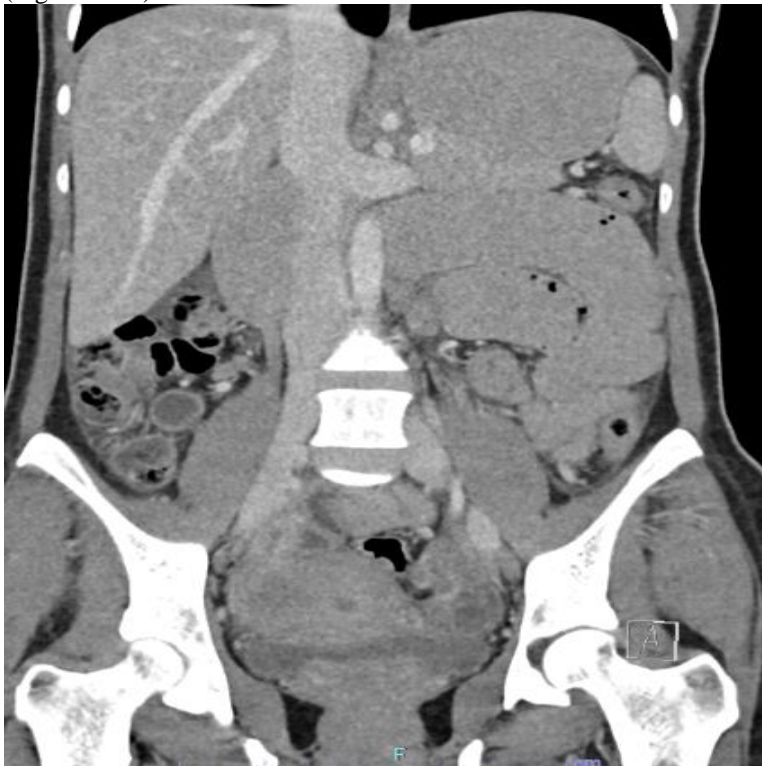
Coronal view on CT scan showing multiple dilated bowel loops.
